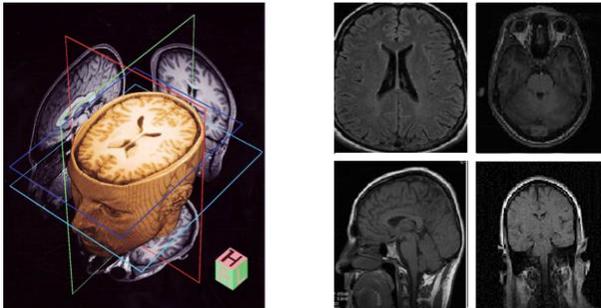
Brain MRI images with different plane/angles to produce multiple modalities
